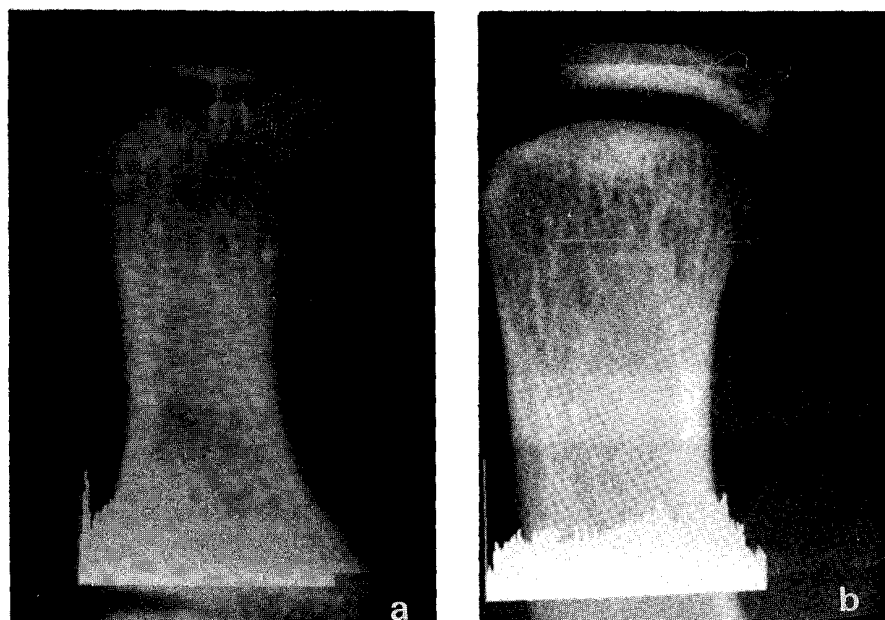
(a) Antemortem radiograph of the right proximal first phalanx; (b) antemortem radiograph of the right first metacarpal.
